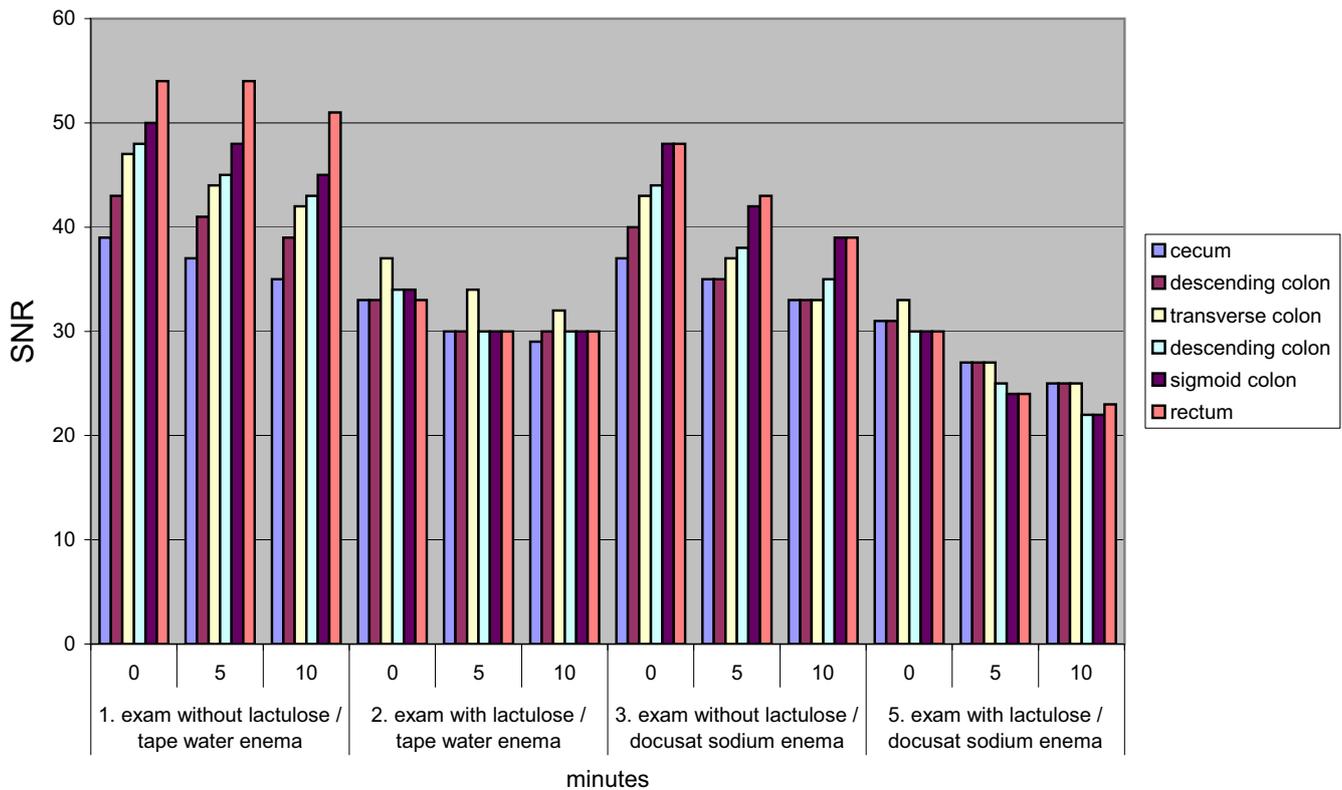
Both substances together decreasing the stool signal intensity by entrance of water in the stool, which has a positive effect on T1-weighted MRI
